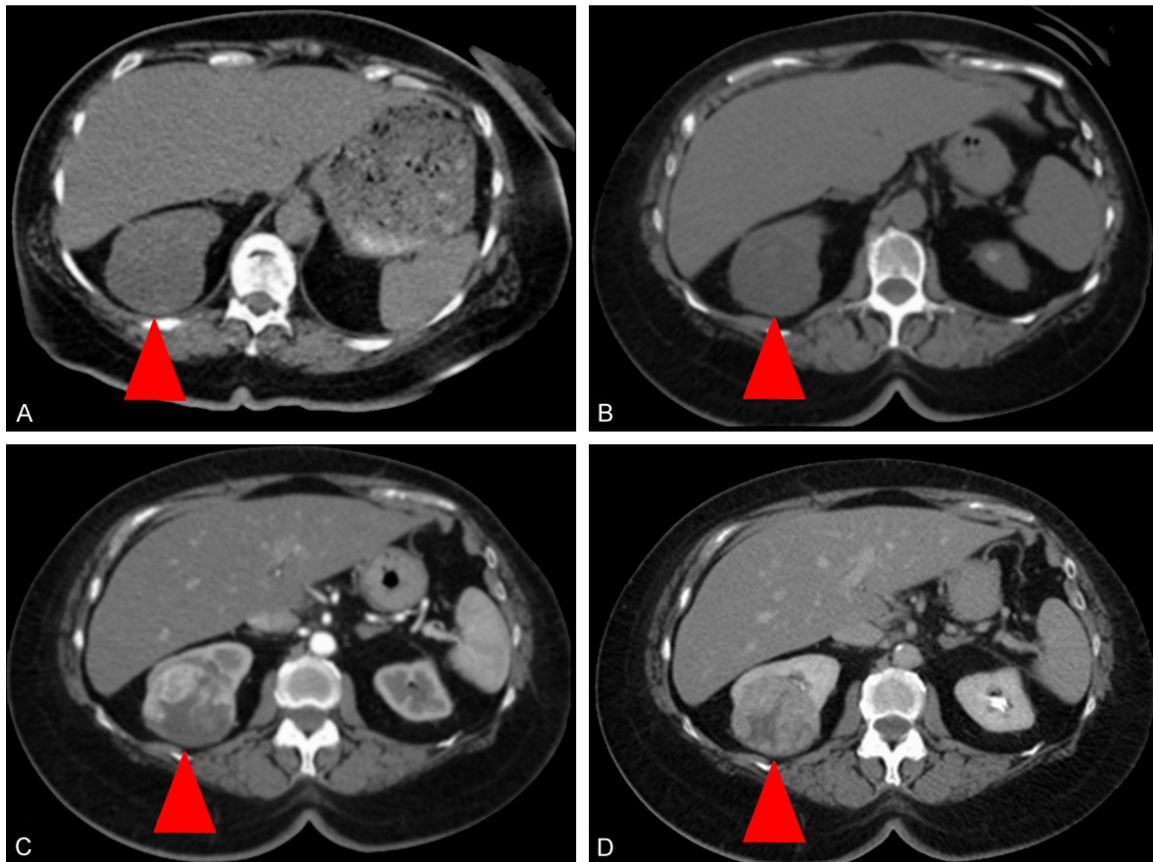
Incidentally-detected renal lesion on SPECT/CT (case 7 above). A. Figure shows a CT of the abdomen through the upper kidneys with a homogeneous-appearing, slightly hypoattenuating mass (red arrowhead) replacing the posterior aspect of the right kidney. This later proved to be a clear cell subtype RCC. B. Noncontrast phase on subsequent renal-protocol CT (note lower noise levels relative to A). As on the original SPECT/CT, the mass (red arrowhead) replaces the posterior aspect of the kidney and is slightly hypoattenuating. C. Arterial phase on subsequent renal-protocol CT. The mass (red arrowhead) is now clearly seen and heterogeneous in appearance. D. Nephrographic phase on subsequent renal-protocol CT. The mass (red arrowhead) is again clearly seen and heterogeneous.
